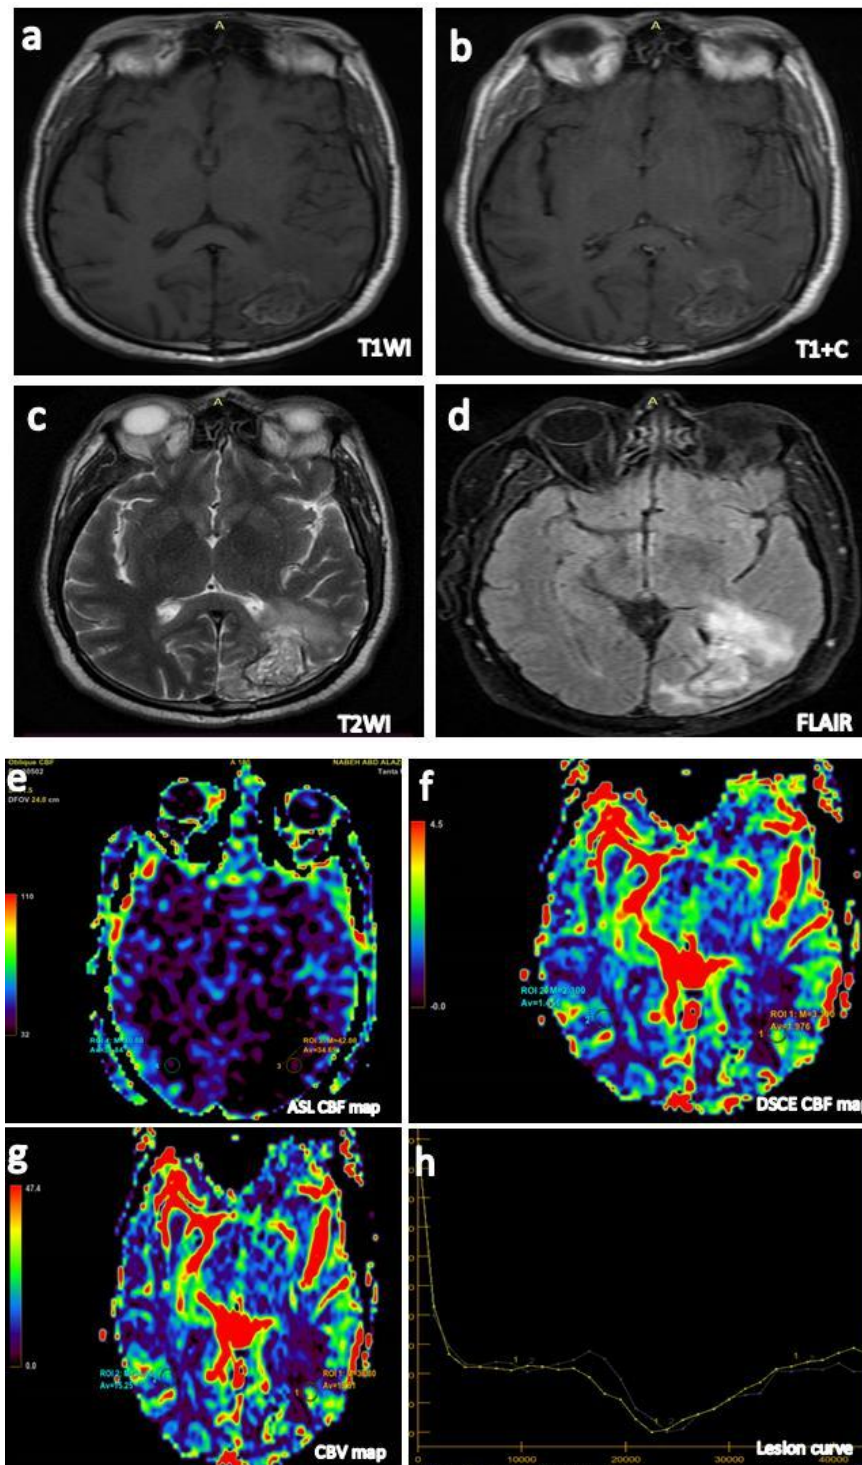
Post- radiotherapy MRI of the brain(axial views) shows an ill-defined hemorrhagic mildly-enhancing intraaxial SOL in the left occipital lobe, displaying high signal on T1WI,measures about 3.7 x 2.3 cm in its maximum dimensions , high signal on T2WI and FLAIR sequence and is surrounded by mild perifocal edema, both exert mass effects with effacement of the overlying cortical sulci and attenuation of the occipital horn of left lateral ventricle and the lesion shows a signal void hemosiderin rim in all sequences(a-d). ASL and DSC color maps show a hypoperfused lesion in comparison with the contralateral brain white matter with ASL r CBF=1.1, ASL CBF absolute value = 40 ml /100 gm/min, DSC r CBF =1.1, DSC CBF absolute value = 29 ml/100 gm/min, DSC rCBV =0.7(e-g) and the lesion signal to time curve shows signal changes similar to that of the contralateral normal brain white matter (yellow and blue curve in h respectively).
